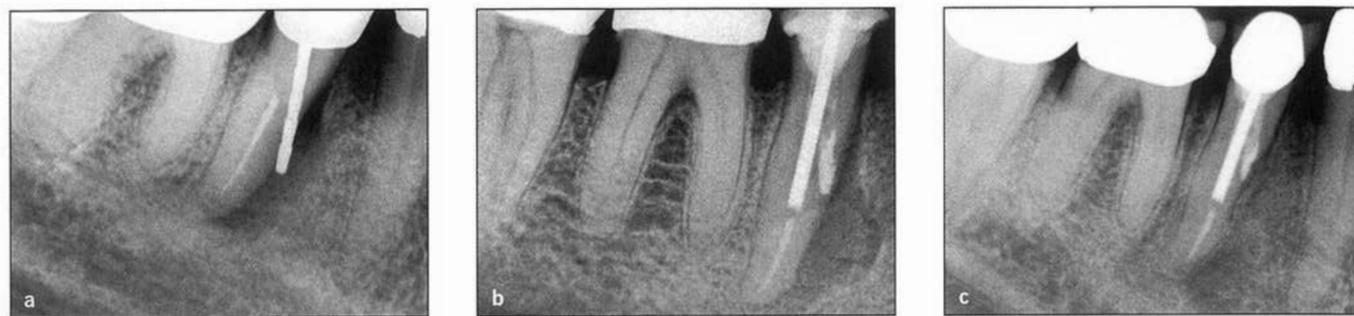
(a) Preoperative radiograph of a mandibular premolar with midroot post perforation. (b) Postoperative radiograph after root canal treatment, placement of a post in the canal, and repair of the perforation with MTA. (c) Postoperative radiograph 3 years later showing resolution of the lateral lesion. The tooth had no clinical symptoms. (Courtesy of Dr Noah Chivian, West Orange, New Jersey.)
